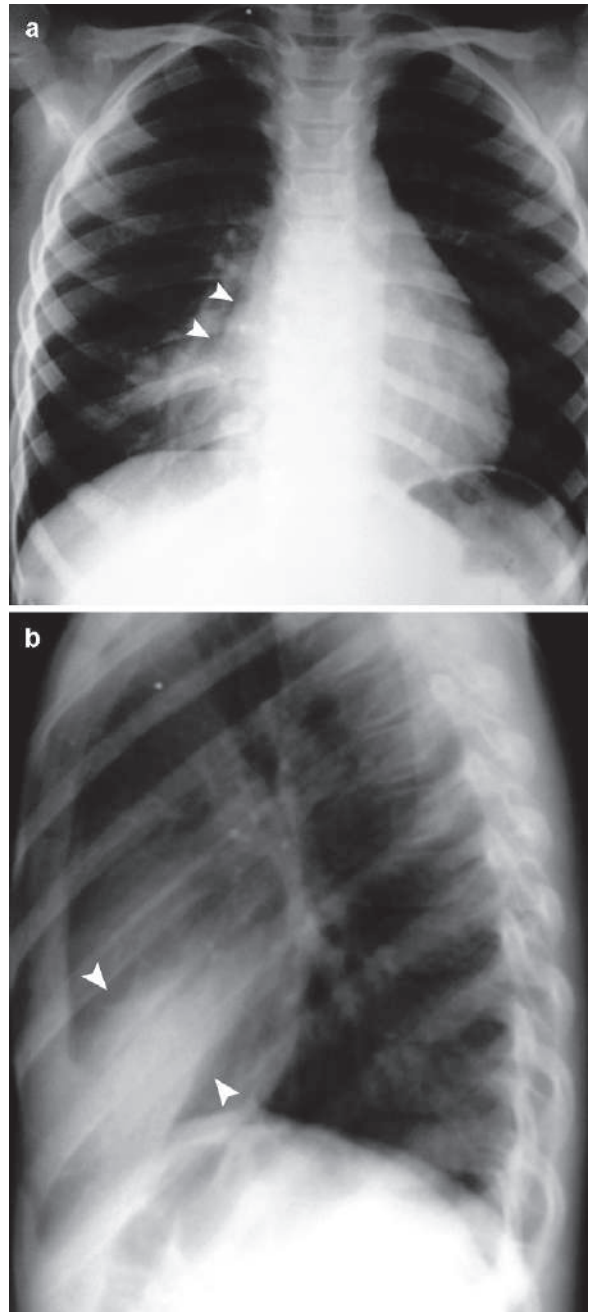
Posteroanterior (a) and lateral (b) plain chest radiographs show right middle lobe (RML) atelectasis (arrowheads)
